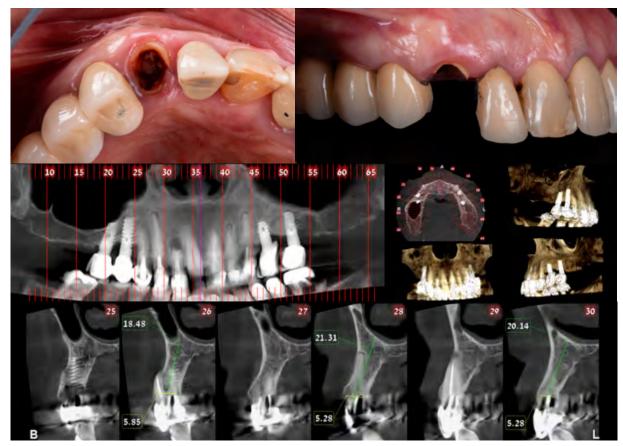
Pre-operative CBCT of tooth 1.3 with periapical lesion and thin buccal plate.
